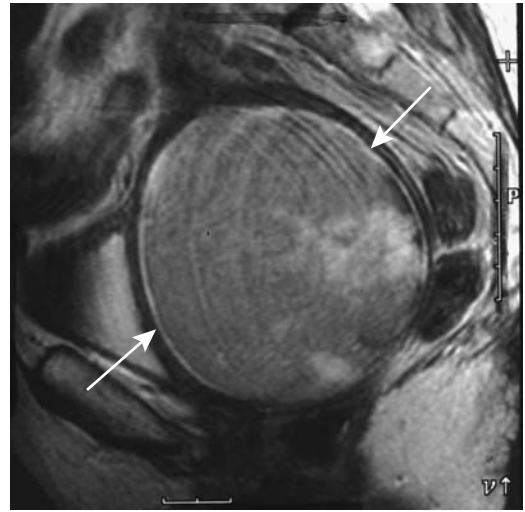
Pyometra secondary to an obstructed cervix. Sagittal T2-weighted MR image reveals a greatly distended uterus (arrows). Blood and debris account for the slightly hyperintense appearance. (Source: Burgener FA, Meyers SP, Tan RK, Zaunbauer W. *Differential Diagnosis in Magnetic Resonance Imaging*. Stuttgart: Thieme, 2002, with permission.)
